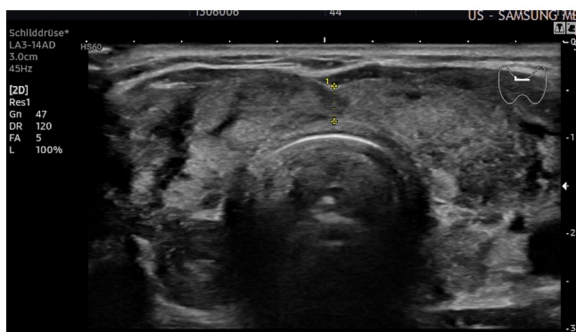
Thyroid sonography at the time of initial presentation. A voluminous thyroid gland with a highly inhomogeneous, predominantly hypoechoic structure can be seen.
